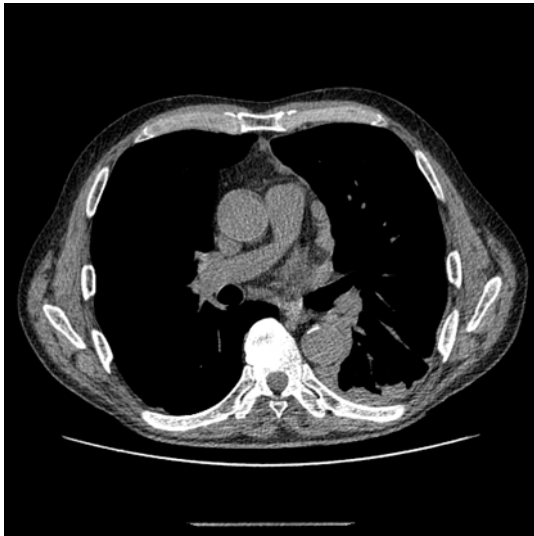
Chest CT angiography: suspicion of masses in left pleura
